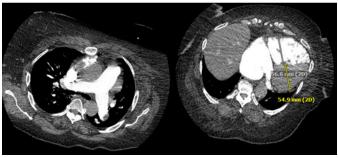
Computed tomography pulmonary angiogram showed bilateral pulmonary embolism and enlarged right heart chambers with reflux of contrast within the hepatic veins.
